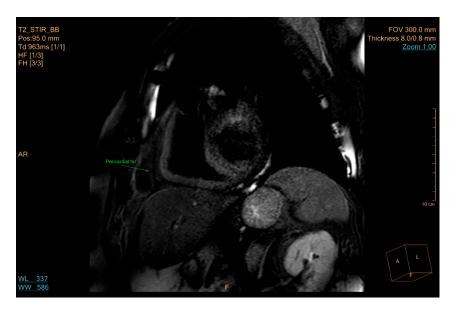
Cardiac MRI Philips Ingenia 3Tardiac T2-STIR sequence, short-axis view, 8 mm, showing hypointensity lateral of right ventricle signifying adipose tissue. Prepared by the authors. Courtesy of the Pediatric Clinical Hospital Sibiu, Lucian Blaga University of Sibiu.
